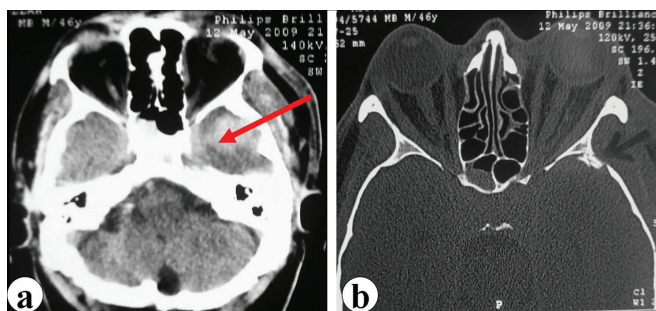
CT scan showing (A) a cerebral contusion in the left temporal lobe (asterisk) and (B) a fracture of the left temporal bone (arrow).
